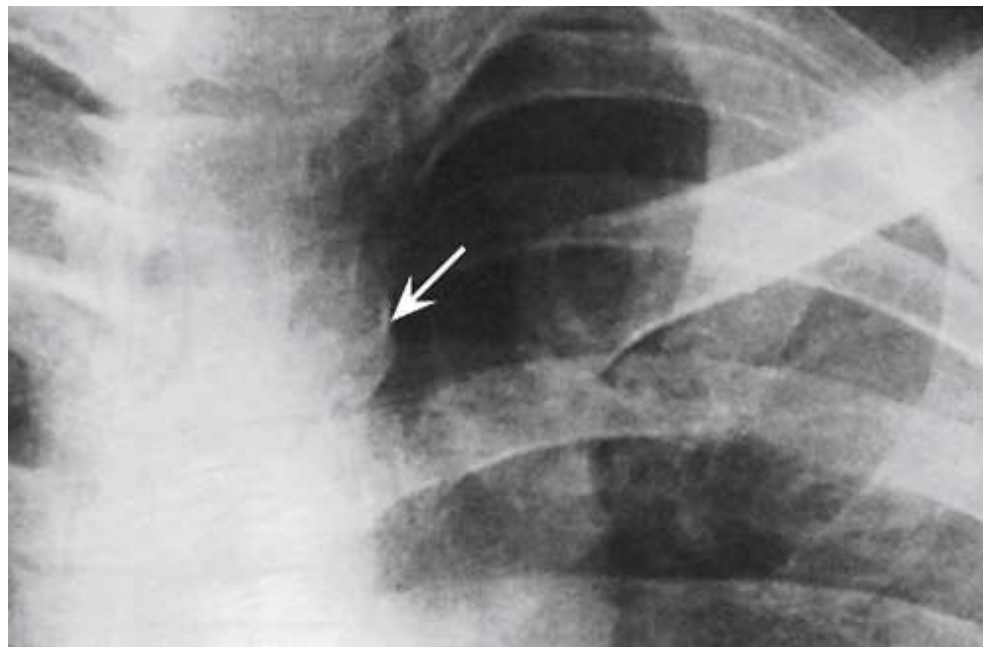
Central ray angulation method for sternoclavicular joint (*arrow*). From Kurzbauer R. The lateral projection in the roentgenography of the sternoclavicular articulation, *AJR Am J Roentgenol.* 1946;56:104.
